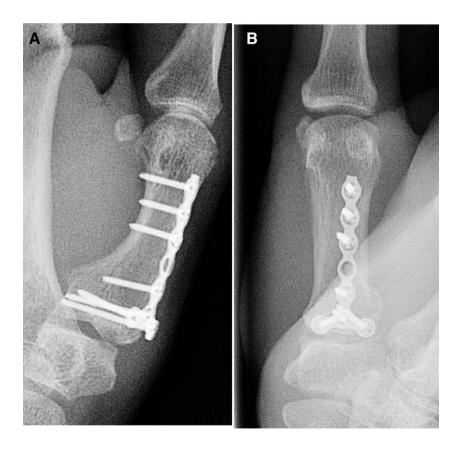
Lateral (A) and anteroposterior (B) radiograph following Bennet fracture open reduction and internal fixation (ORIF)
